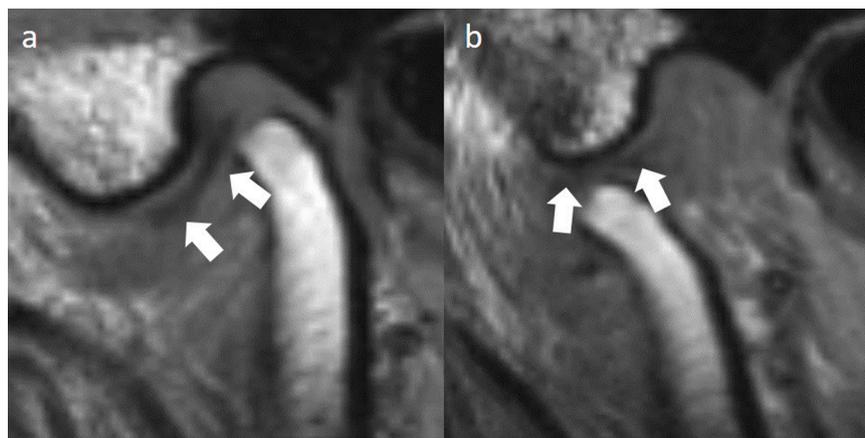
T1-weighted static images of the left temporomandibular joint of a 52-year-old male patient with anterior displaced disc (arrows). Anteriorly (11 o'clock) positioned disc with contact to the condyle in closed mouth position (a). At open mouth position the condyle is located on the disc (b). The translation of the condyle and disc is reduced.
